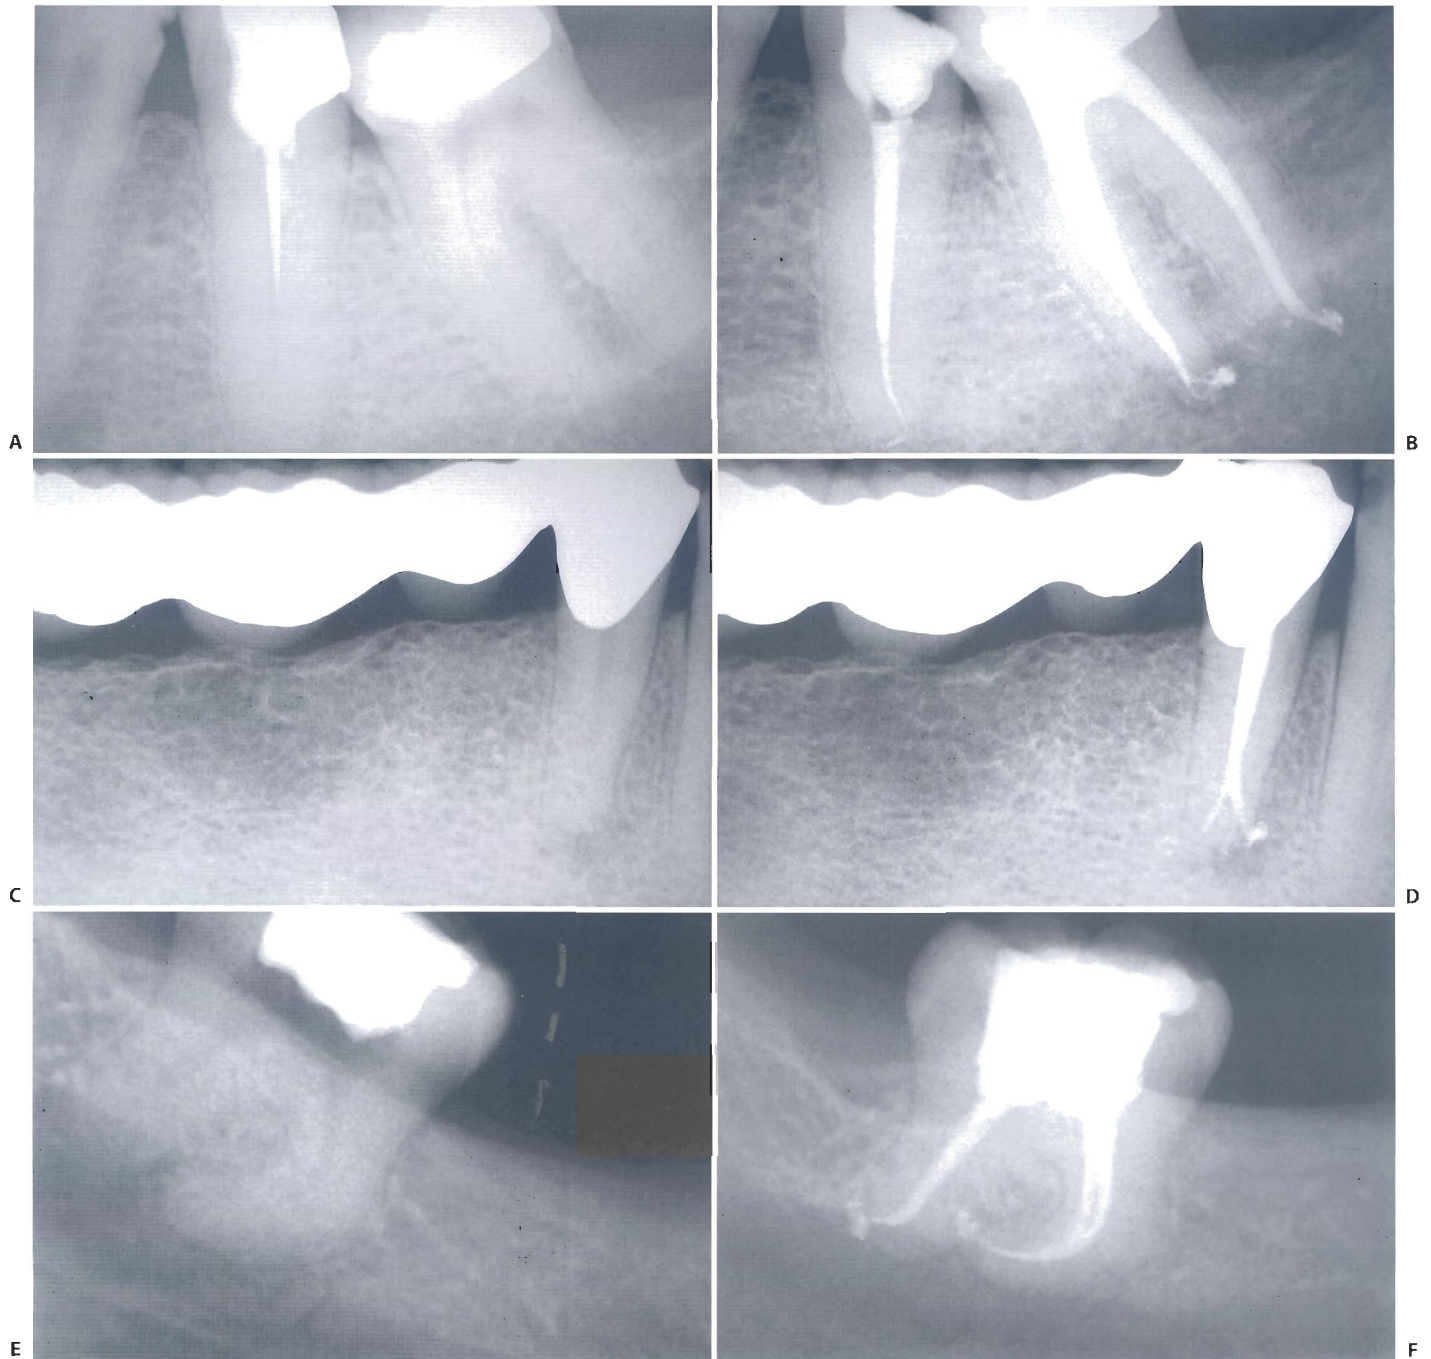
Clinical cases of teeth with canals having an original complex anatomy in the apical one third. In these cases it is wise not to force the rotary NiTi instruments to the terminus of the canal. A. Preoperative radiograph of a lower left first molar. B. Postoperative radiograph (E. Berutti). C. Preoperative radiograph of the lower right first premolar. D. Postoperative radiograph (E. Berutti). E. Preoperative radiograph of the lower right third molar. F. Postoperative radiograph (G. Cantatore).
